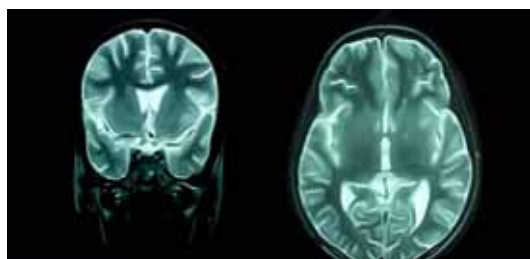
Coronal and axial T2-weighted MR image showing discrete high signal lesion in both insular. High signal lesions were also seen in right parietal and occipital subcortical white matter.
